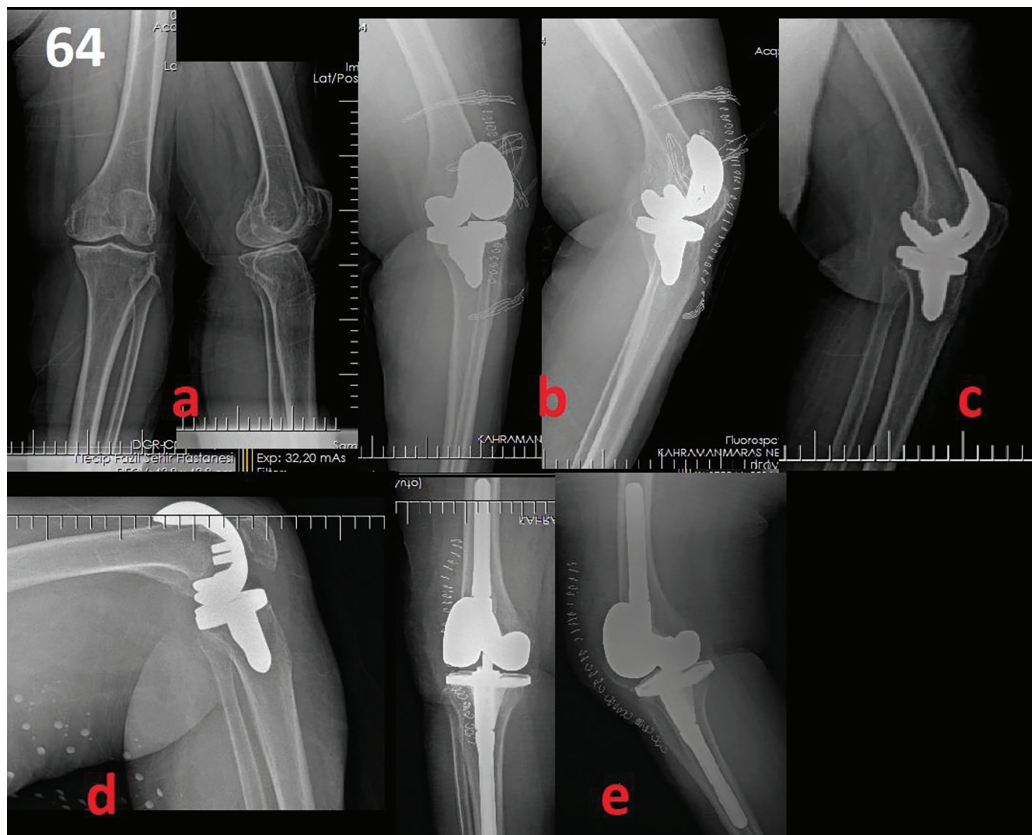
a) Fifty-five year old man with grade 2 arthritis b) Postoperative X-rays c) Extension loss of 40 degrees d) Flexion deformity can be seen at fifth month e) One stage revision has been made
